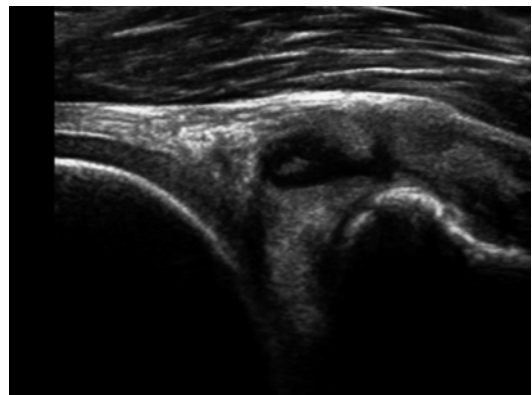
Ultrasound parameniscal cyst with medial meniscus lesion and chondropathy
